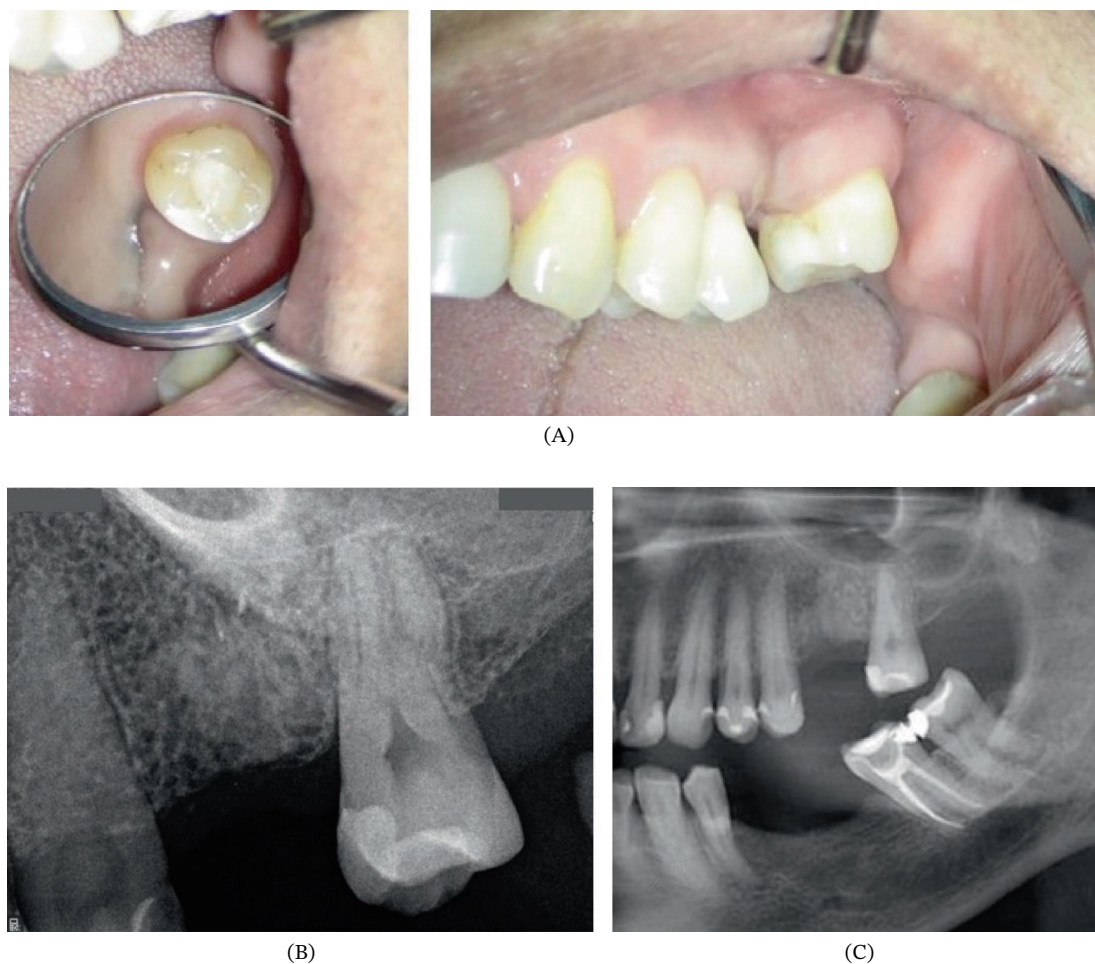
Eight-month follow-up evaluation of the maxillary second molar. (A) Intraoral photograph demonstrating complete healing of the adjacent soft tissues, with no evidence of swelling or inflammation. (B) Periapical radiograph showing absence of periapical or periodontal pathology and maintenance of normal periapical structures. (C) Panoramic segment confirming the absence of pathological changes associated with the affected tooth and preservation of surrounding supporting structures.
